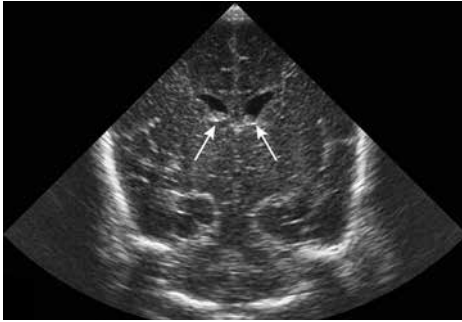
Coronal ultrasound scan at the level of the frontal horns of the lateral ventricles performed with phased array transducer, showing a good near-field but less far-field resolution (preterm infant, gestational age 29 wk). Bilateral grade 1 intraventricular hemorrhage (arrows) and mildly dilated frontal horns.
